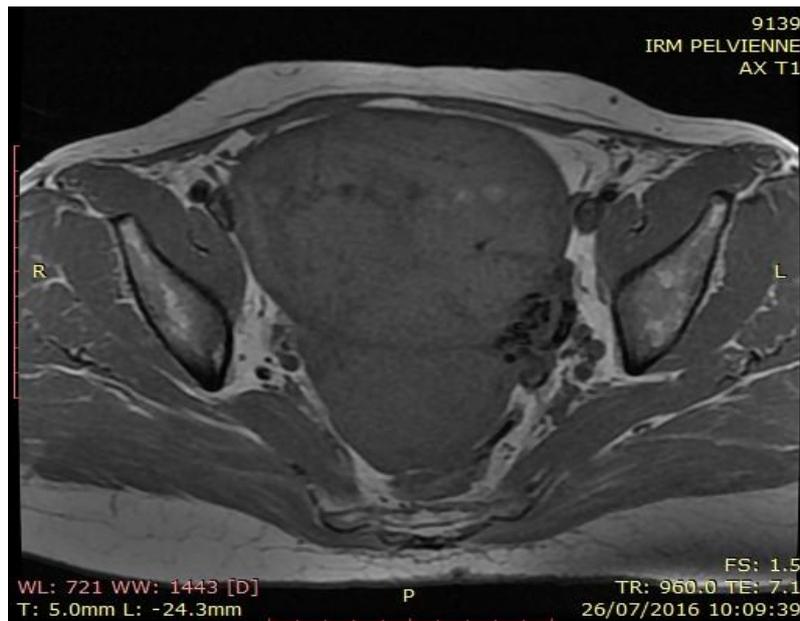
Images of MRI showing heterogeneous right supra-latero-uterine mass.
